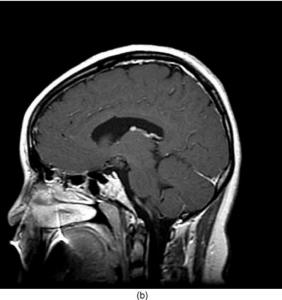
Sagital postgadolinium enhanced magnetic resonance imaging (MRI) images of an adolescent with a suprasellar secreting germ cell tumour at presentation (a) and 2 years following successful treatment with chemotherapy and focal radiation (b). Severe fluid and electrolyte abnormalities, encountered following the administration of cisplatin, ifosfamide and etoposide-containing chemotherapy, on the background of diabetes insipidus, resolved with appropriate management.
